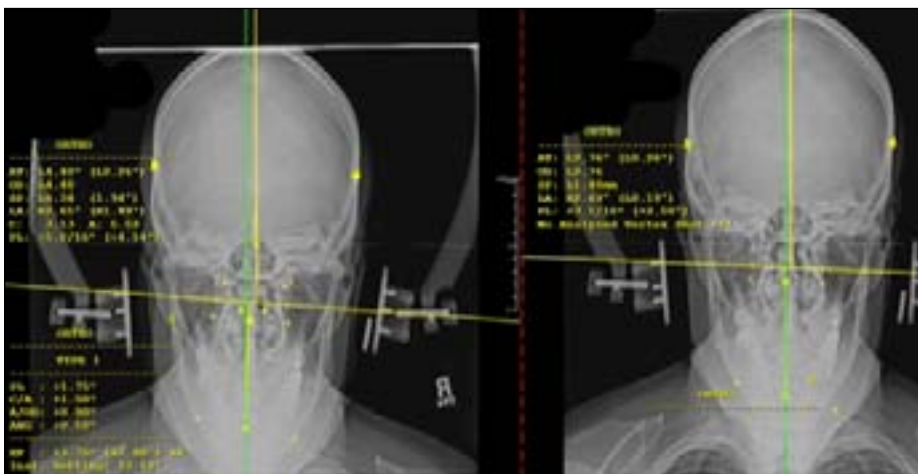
CCJ X-Rays Showing Pre (left) and Post (right) Upper Cervical Adjustment
